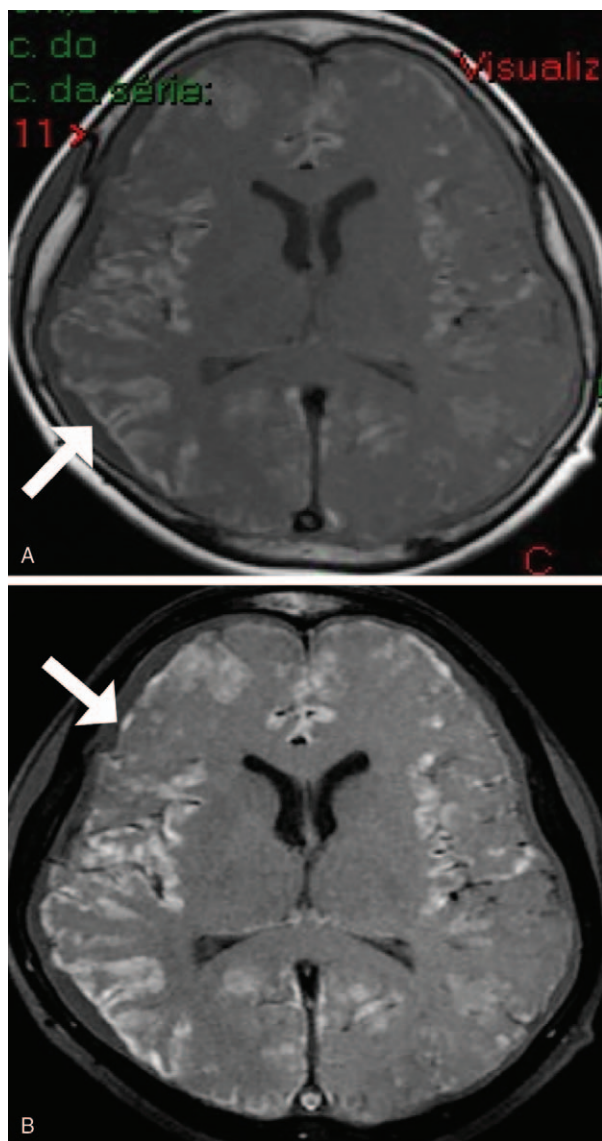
12-Year-old man with neurocutaneous melanosis. Axial unenhanced (A) and contrast-enhanced (B) T1-weighted images show signal hyperintensity, slight contrast enhancement, and thickening of the leptomeninges of the right greater than left cerebral hemispheres (white arrows).
